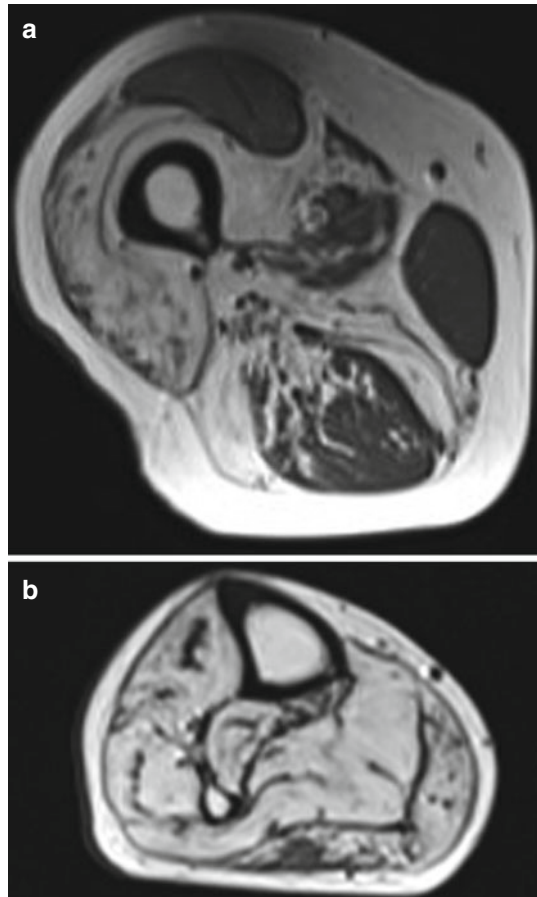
Lower limb MRI. Transverse T1 weighted images through the right thigh (a) and calf (b). In the thigh marked sparing of rectus femoris, semitendinosus and gracilis is seen with relative sparing of lateral gastrocnemius in the calf
